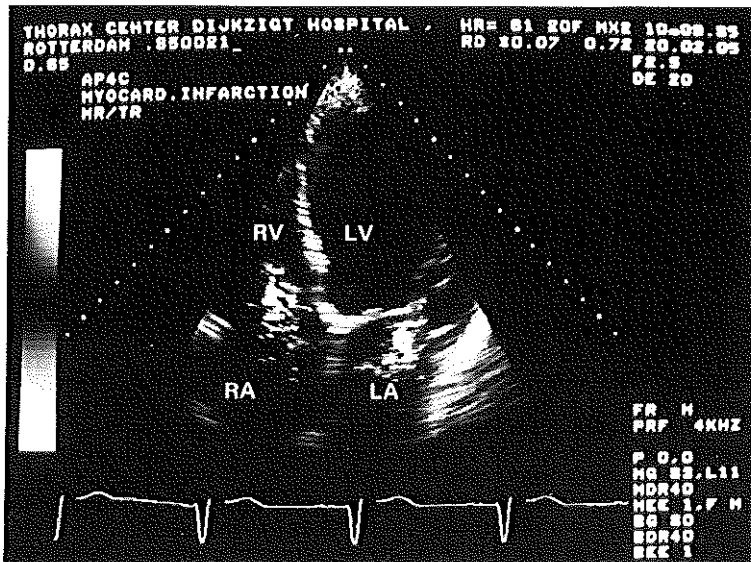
Combined mitral and tricuspid insufficiency in inferior myocardial infarction involving the right ventricle, visualized with the color Doppler flow imaging system in systole. Note the two jets behind the atrioventricular valves in the apical four-chamber view. *LV*, left ventricle; *LA*, left atrium; *RV*, right ventricle; *RA*, right atrium.
